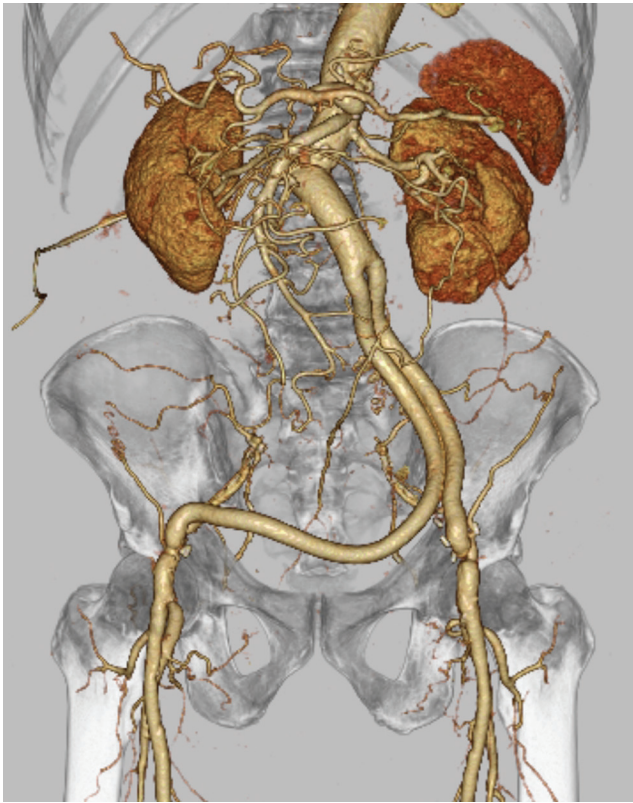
Postoperative computed tomography scan showing the reversed L-shaped graft.
